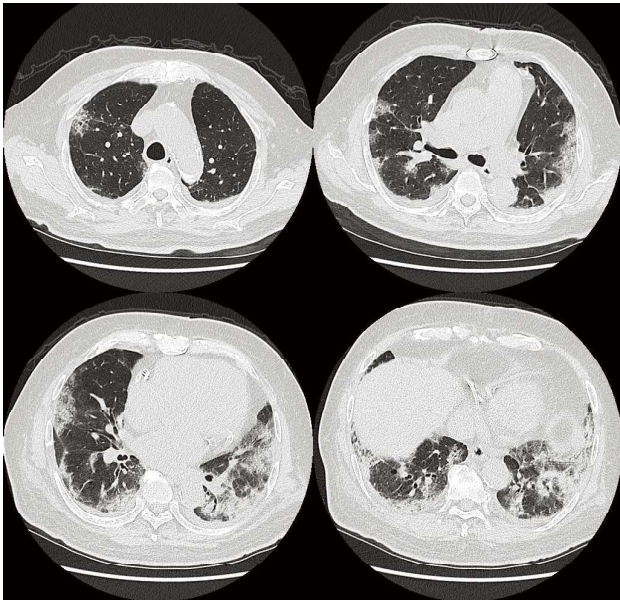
Admission CT shows bilateral subpleural and peribronchovascular ground glass opacities and consolidation with bilateral minimal amount of pleural effusion.
